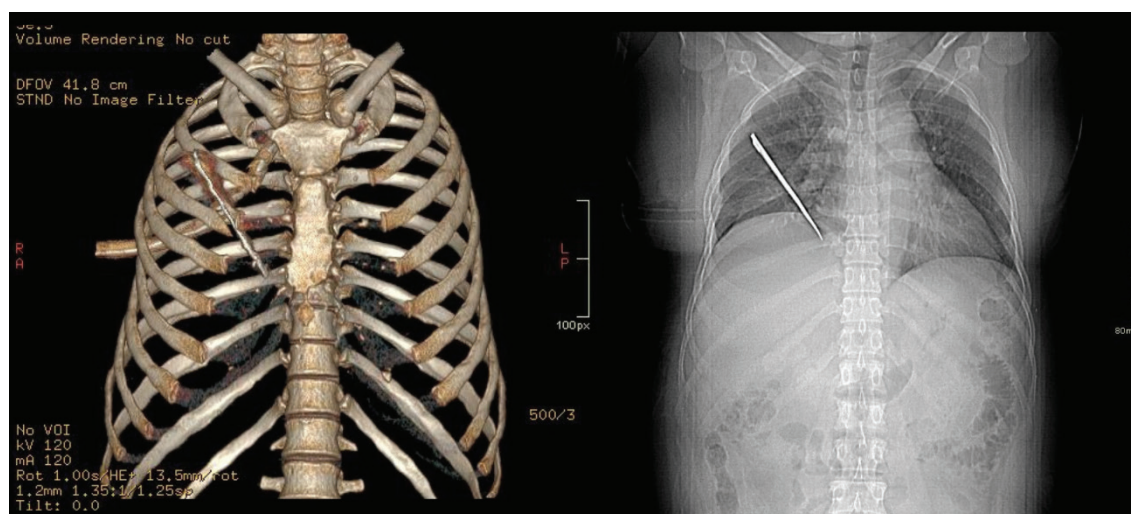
Chest X-ray and 3D CT reconstruction showing the course of the knife trauma.
